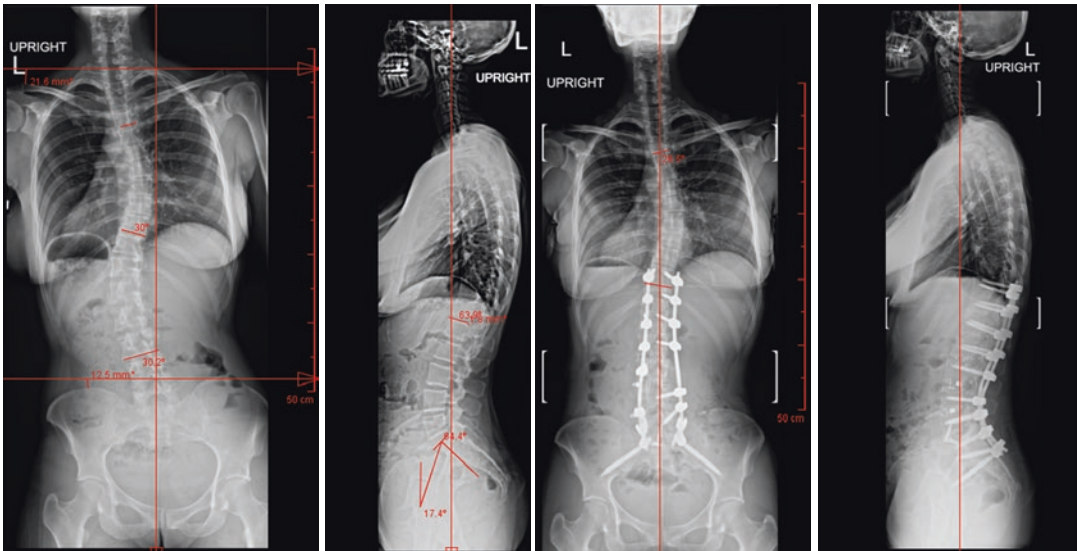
Preoperative standing AP and Lateral Scoliosis X-rays (left) and postoperative standing AP and Lateral Scoliosis X-rays (right) demonstrating coronal alignment correction and maintenance of sagittal balance
